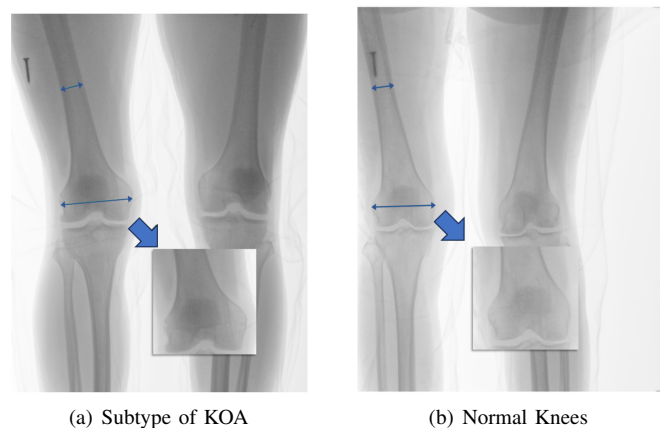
Comparative radiographs of special knee osteoarthritis subtypes. (a) Demonstrates characteristic findings of the Subtype, including proximal femoral shaft narrowing, marked epiphyseal broadening with cup-shaped deformity, and irregular articular margins with undulating contours. (b) Shows typical Normal knee presentation with preserved femoral morphology and smooth articular surfaces.
